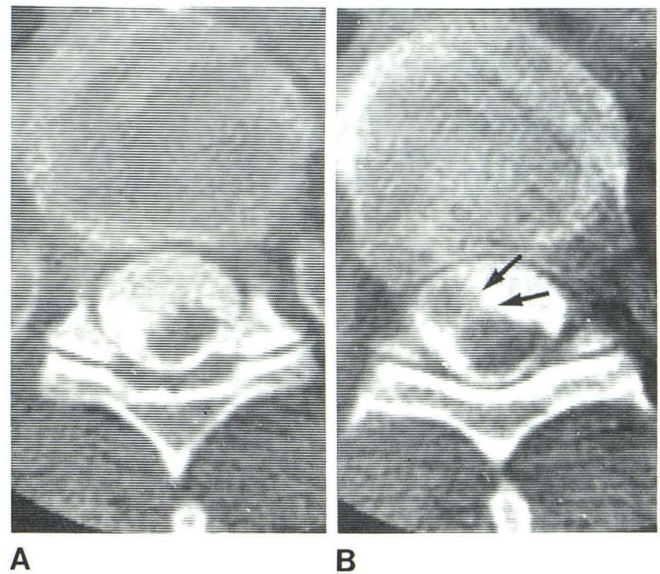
Thoracic meningioma in 69-year-old man. CT myelography. A, At T10 level. Spinal cord is located eccentrically on posterior aspect of thecal sac to left of midline. B, At T9 level. Lobulated intradural extramedullary mass (arrows) on right anteriorly displaces and compresses cord posteriorly and to left.
